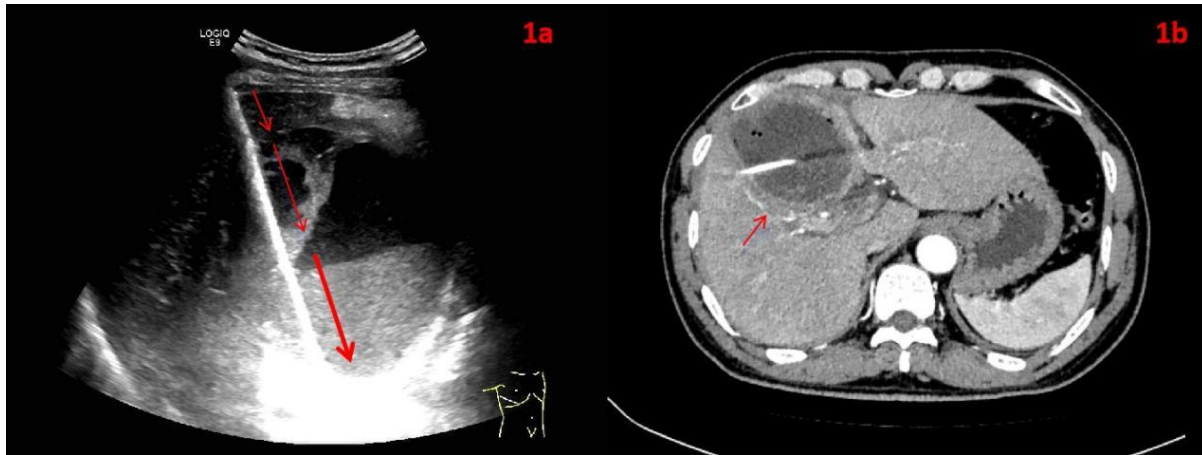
(1a) Under the guidance of color Doppler ultrasound, the puncture trajectory traversed the peripheral liver tissue and the purulent lesion in the gallbladder bed, with the guidewire being successfully positioned within the gallbladder cavity. (1b) Postoperative CT evaluation confirmed that the drainage catheter was accurately placed in the gallbladder, and no evidence of hematoma or pseudoaneurysm was observed along the puncture pathway (arrow).
